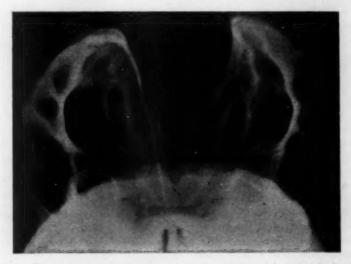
Postmortem roentgenogram demonstrating craniolacunia of the frontal bones.
